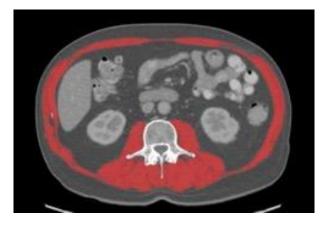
A single CT slice at the third lumbar (L3) area<sup>\*</sup>. Skeletal muscle crosssectional area, is indicated in red.
